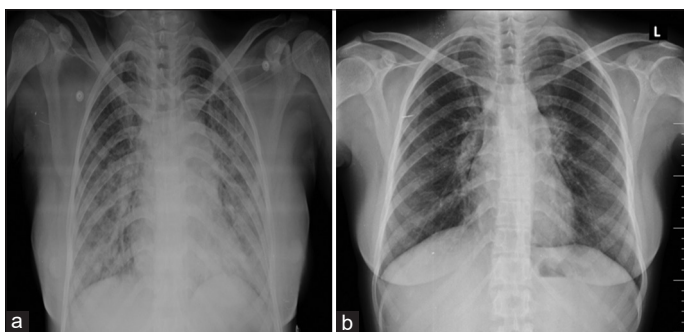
(a) Chest X-ray shows bilateral all zones ill-defined non-homogenous opacities with cardiomegaly; (b) Follow-up chest X-ray shows resolution of opacities
